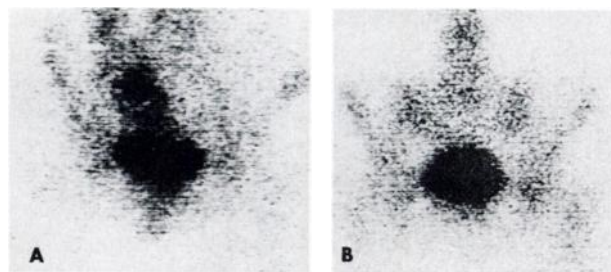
Woman aged 56 with synovial sarcoma in left tibia. Pelvic x-ray showed uncharacteristic increased density in right side of pelvis where poorly defined tumor could be palpated. Scintigram using Tc-PP (A) showed pronounced extensive uptake corresponding to tumor; ^{18}F scintigram (B) showed only slightly increased uptake to right above bladder. Metastases to pelvis were suspected, but biopsy from pelvic tumor showed lymphangioma. Femoral amputation was carried out.
